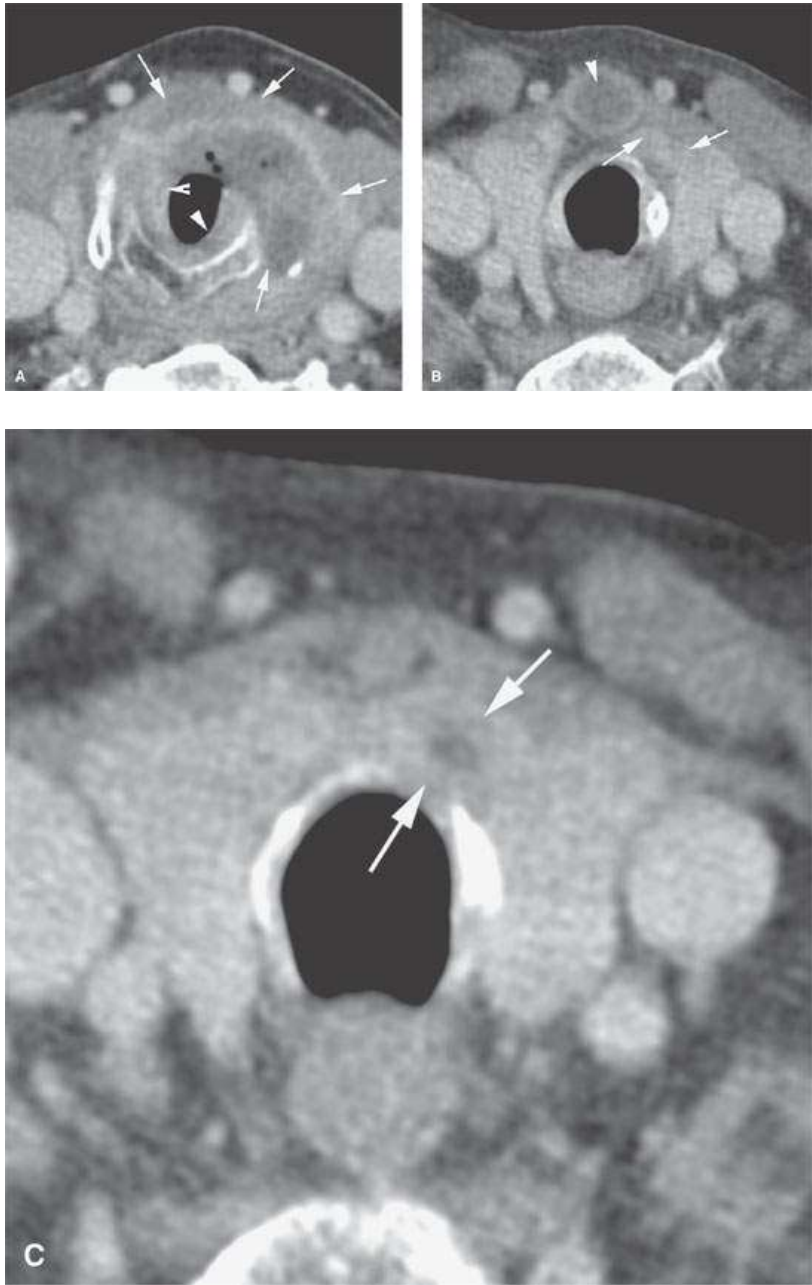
Contrast-enhanced computed tomography study of a patient presenting with acute respiratory distress due to advanced laryngeal carcinoma. The tumor arises on the true vocal cords. A: The mid subglottis is filled with tumor (arrowheads), which spreads extensively outside the larynx. B: Tumor had spread to a prelaryngeal level six lymph node (arrowhead) as well as directly to the soft tissues of the neck around the thyroid isthmus (arrows). This image is at the level of the first tracheal ring. C: An image at the level of the second tracheal ring remains suspicious for tumor spread outside the larynx and involvement of the tracheal ring (arrows). This image was at the level of the second tracheal ring. (NOTE: If possible, diagnostic imaging should be obtained before tracheostomy in patients with advanced laryngeal carcinoma. In this patient, imaging helped decision making with regard to placing the tracheostomy tube lower than usual to avoid its passing through gross tumor.)
